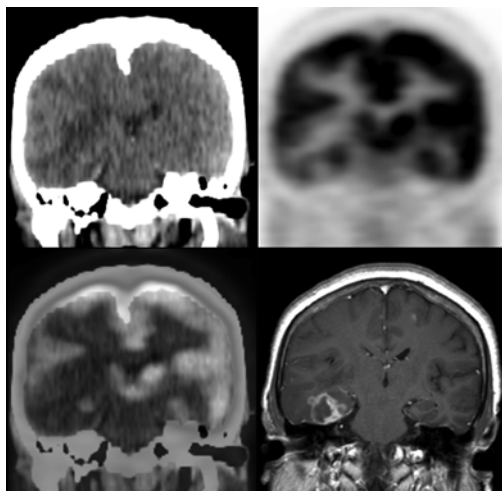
Figure two depicts CT, PET, fused PET/CT, and MRI (T1 sequence post Gadolinium) coronal images showing the largest lesion in the right temporal lobe measuring 2.4 x 1.9 cm which demonstrates irregular peripheral enhancement and correlates to the area of hypometabolism on PET.
